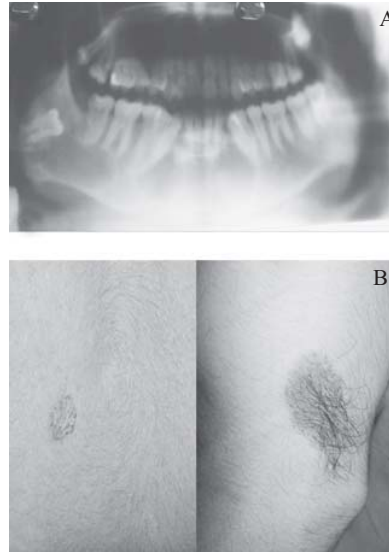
A) Orthopantomograph depicting multiple radiolucencies in the mandible B) Basal Cell nevi on the back and thigh
